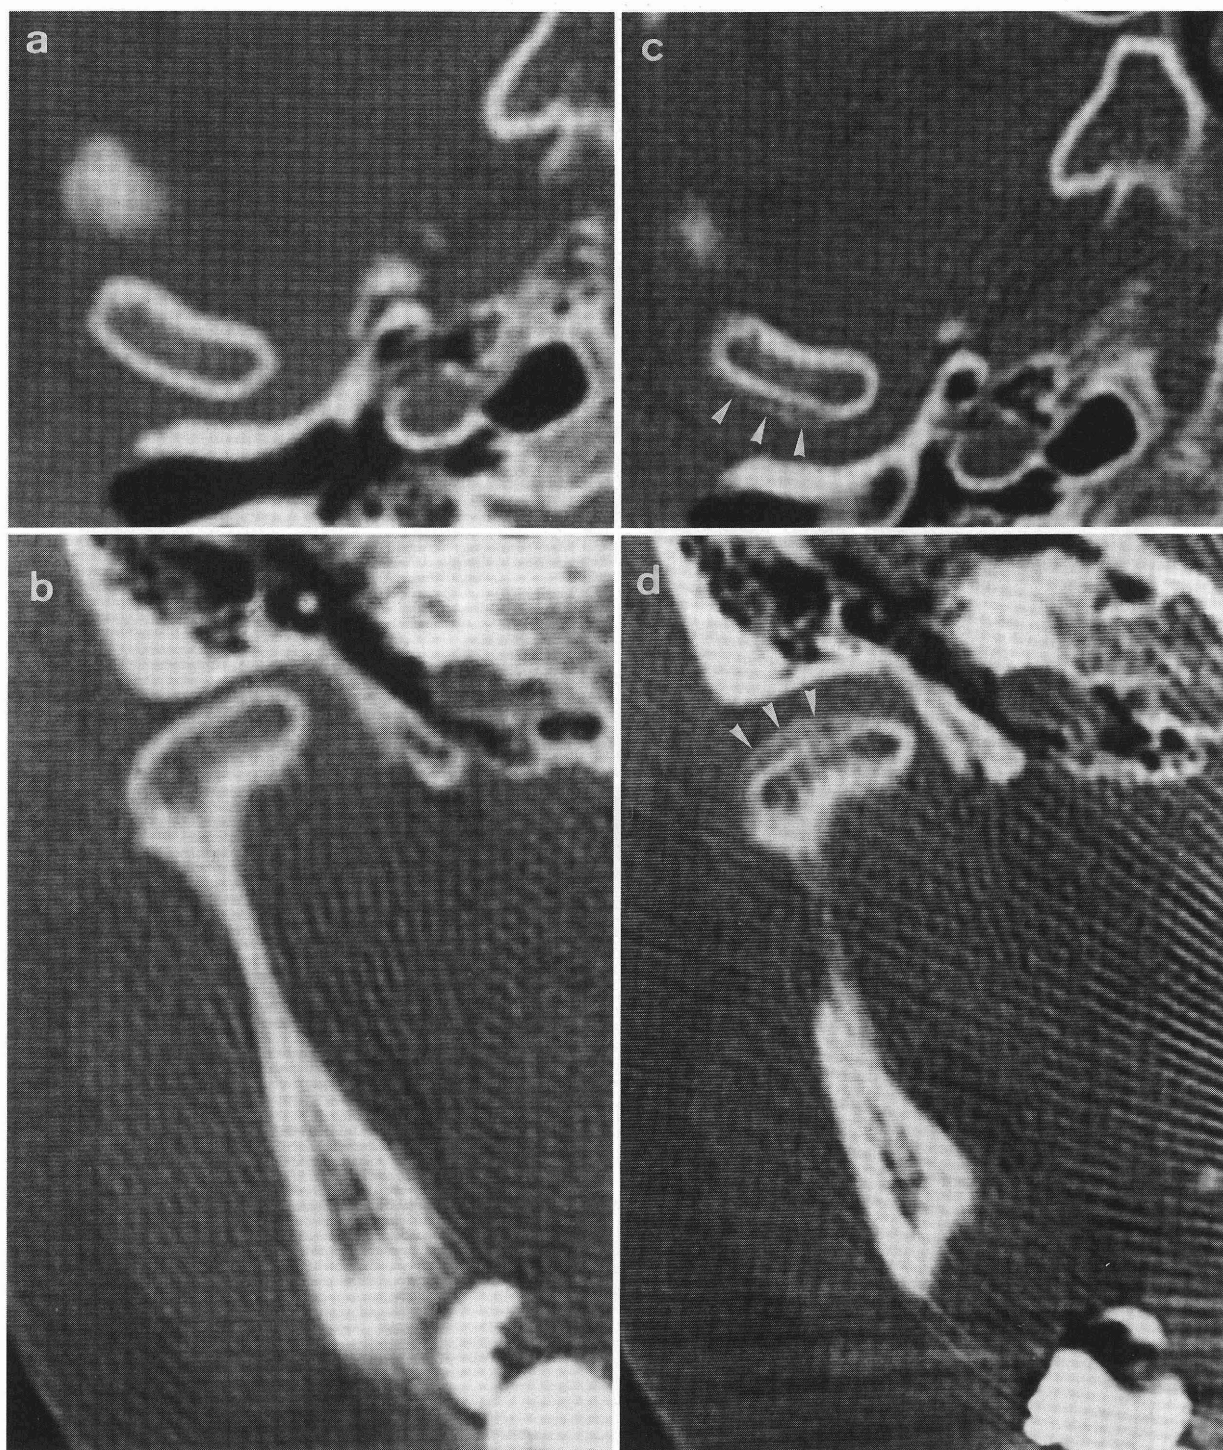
TMJ X-ray computed tomography in axial and coronal (45 degree to RBL) section (case 3). Pre-(a, b) and post-operative (c, d ; post-op. 14 months) images. After IVRO, a double contour line (arrowheads) in the postero-superior part of right mandibular head was observed.
